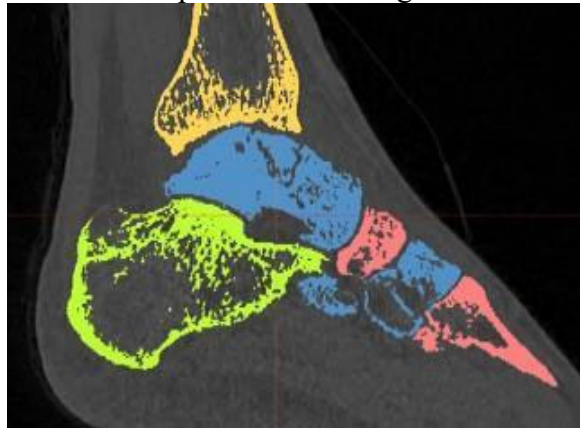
Representative Digital Imaging and Communications in Medicine (DICOM) segmentation of a foot and ankle CT scan.
